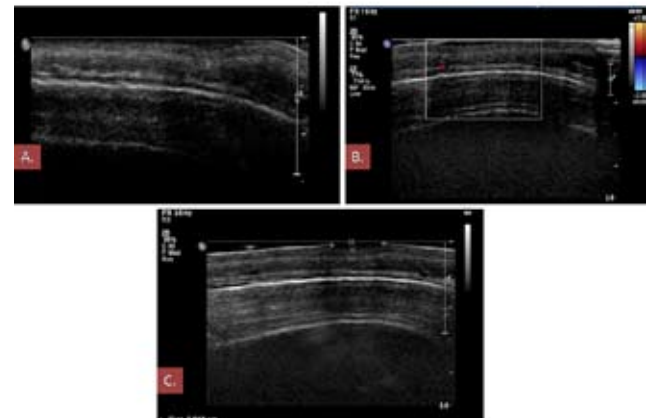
Case 2. US examinations. A. the hypoechoic lesion crossing the dermoepidermal border, poorly-delimited, infiltration of the upper dermal layers with compression of the lower dermal layers and fatty tissue – mass effect – the expansively growing lesion. B. Color Doppler scan visualizing a single signal of vascular flow in the fatty tissue below the lesion. C. The lesion about 8.1x1.2 mm in size.
